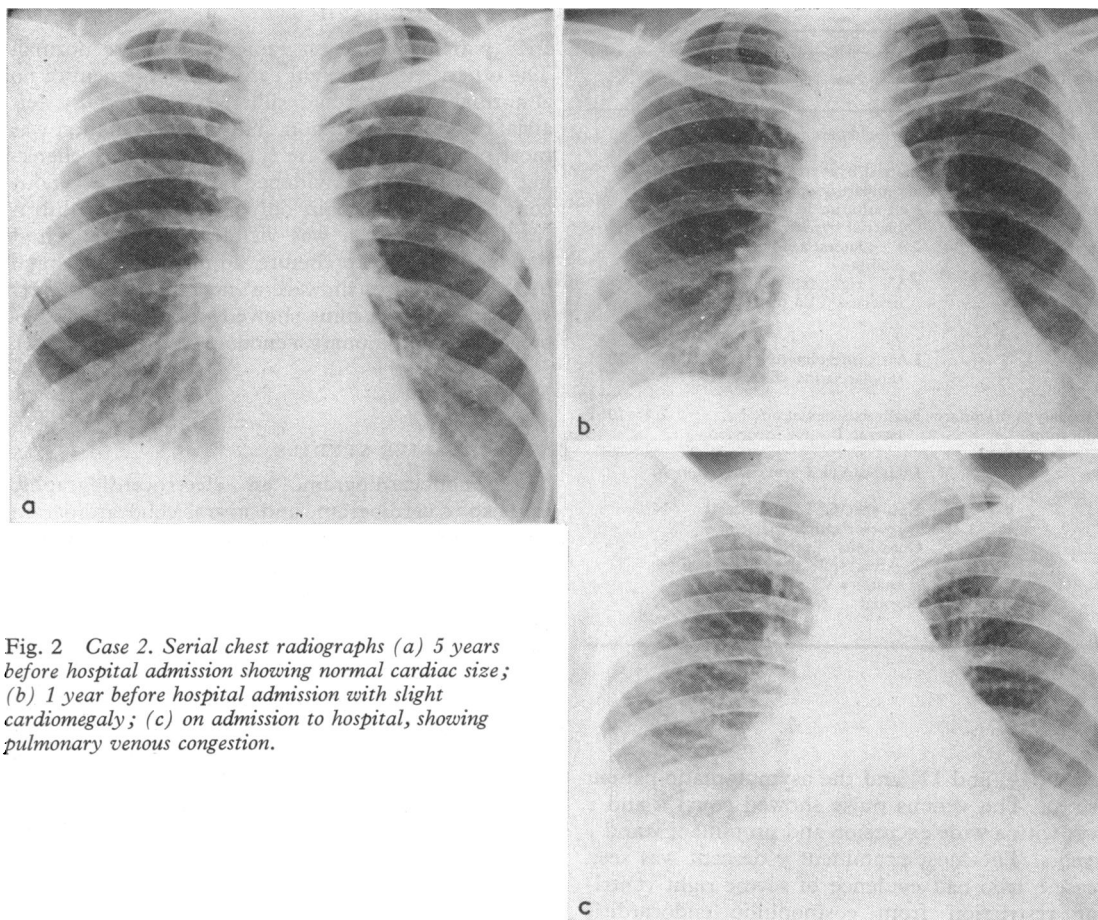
Case 2. Serial chest radiographs (a) 5 years before hospital admission showing normal cardiac size; (b) 1 year before hospital admission with slight cardiomegaly; (c) on admission to hospital, showing pulmonary venous congestion.
